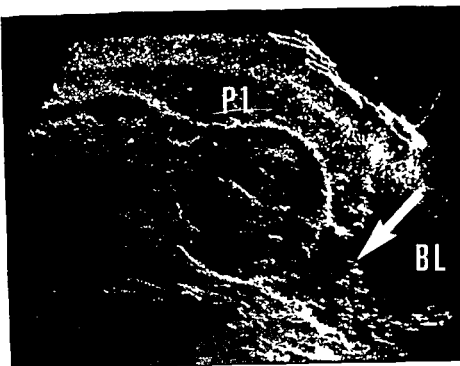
Ultrasonic B scan at the 33rd week from the same patient as in Fig 1 and 2. The degree of placenta previa is further marginal
